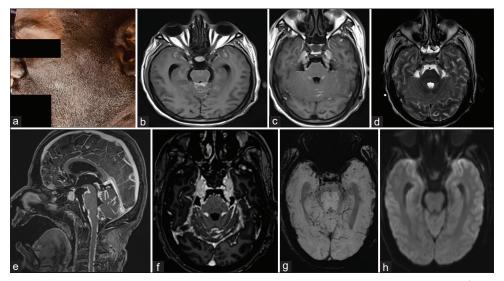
(a). A large nevus with distinct boundaries and uniform pigmentation over the left half of the face. (b and c). T1 (non-contrast) sequence showed hyperintensities over the cerebellar folia and the anterior temporal lobes. Note the intense thickening and T1 hyperintensities over the trigeminal nerve. (d). T2 axial demonstrating thickened trigeminal nerves. The rest of the brain parenchyma was normal. (e and f). T1-Gd+ images showing intense leptomeningeal enhancement over the cranial nerves, brainstem, cerebellum, and spinal cord ("zuckerguss"). (g and h). SWI and DWI sequences did not show areas of abnormal susceptibility or restriction
